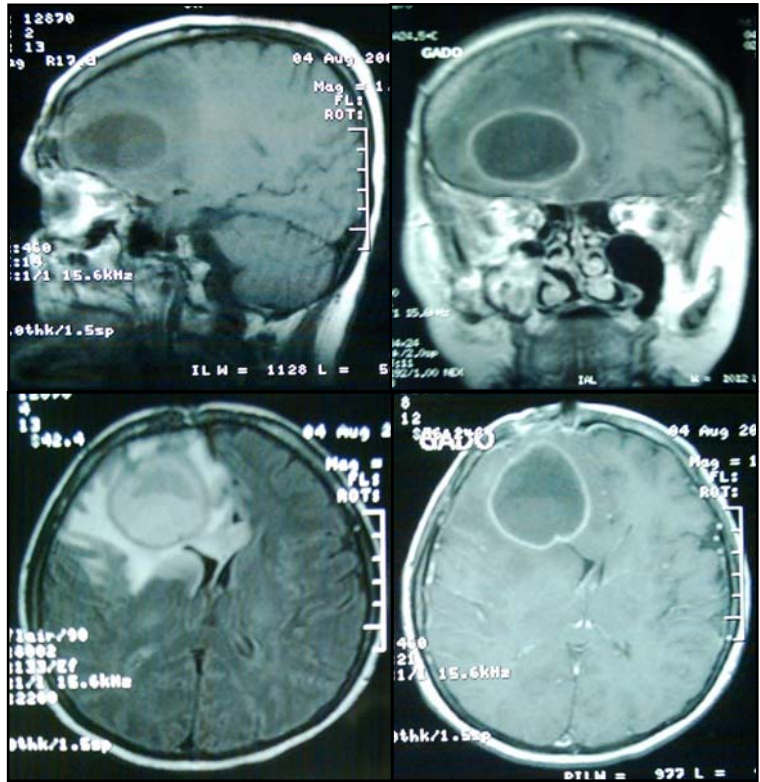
Gadolinium contrasted brain MRI
